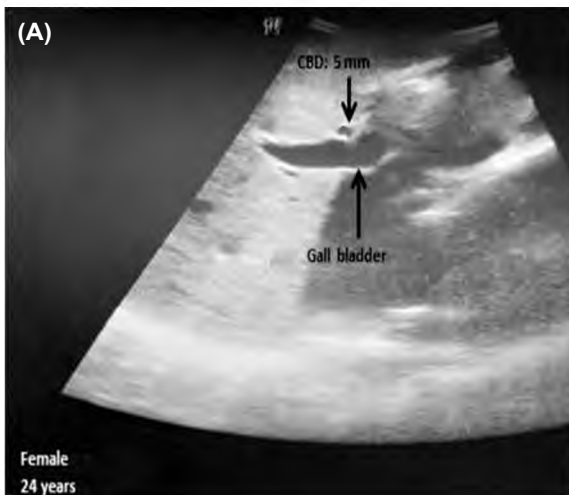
Radiological images of 3 patients between 20 and 50 years of age with healthy GB showing no difference in the diameter of CBD in these age groups with 4.9 ± 0.3 mm diameter of CBD. (A) Trans abdominal ultrasound image of a 24 years old female, (B) MRI image of a 38 years old female, (C) MRCP image of a 44 years old male.
